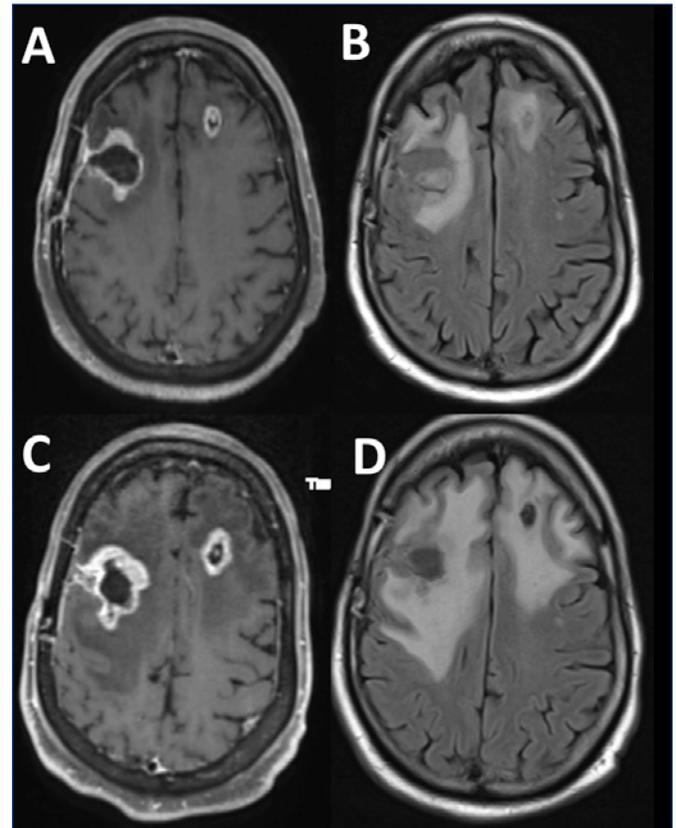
MR images after initial cranial irradiation and after 5 cycles of adjuvant treatment. (A) Post-gadolinium-enhanced T1-weight MP RAGE image showed a slight increase in enhancement near the surgical cavity and the contralateral left frontal white matter. (B) There was noticeable but mild cerebral edema in the right and left frontal white matter. (C) Post-gadolinium-enhanced T1-weight MP RAGE image demonstrated tumor progression in both right and left frontal lobes. (D) There was a marked increase in cerebral edema in the white matter of both frontal lobes.
